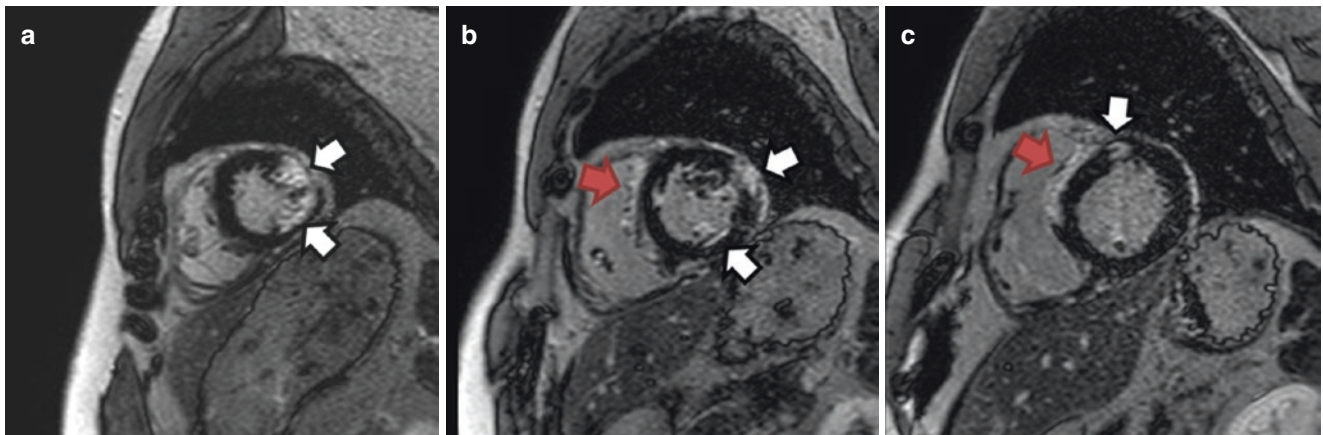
Late gadolinium-enhanced cardiac MRI
